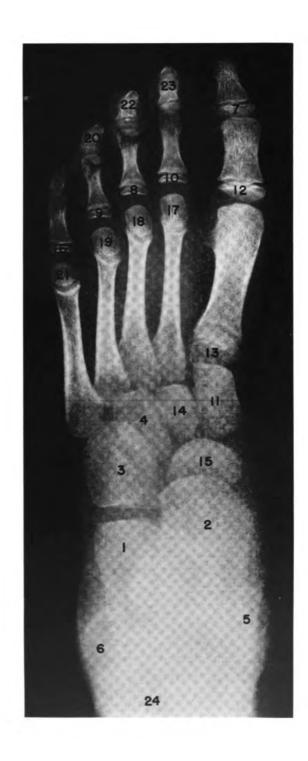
Dorsoplantar radiograph of the foot showing the order of appearance of centers of ossification in the region as a whole. The numbers indicate the order of onset of ossification most frequently seen in boys.
